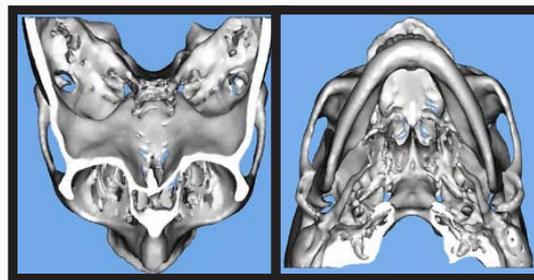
Three dimensional reconstruction of the head CT. A) Superior view demonstrating erosion of the condylar head into the middle cranial fossa. B) Inferior view of the mandible.
